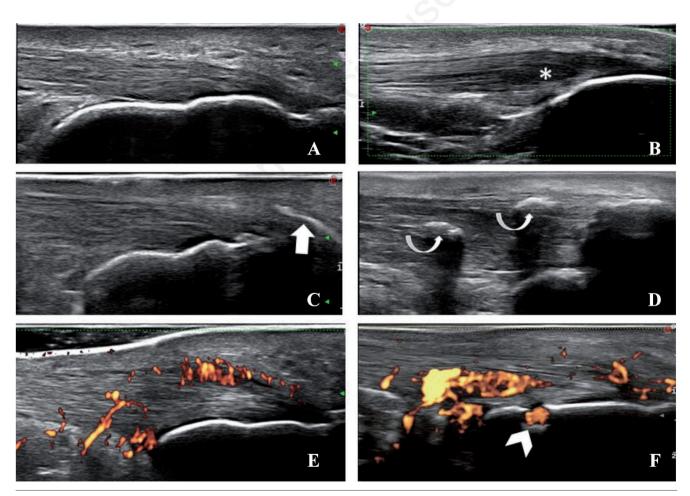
Ultrasound features of grey scale and power Doppler changes in enthesis. A) normal tendon enthesis (Achilles tendon); B) thickening and hypoechogenicity of the tendon insertion (asterisk); C) enthesophyte (arrow); D) tendon calcifications (curved arrows); E) power Doppler signal in the insertional tract of the tendon; F) power Doppler signal and erosions of calcaneal profile (typical aspect of enthesitis in spondyloarthritis).
